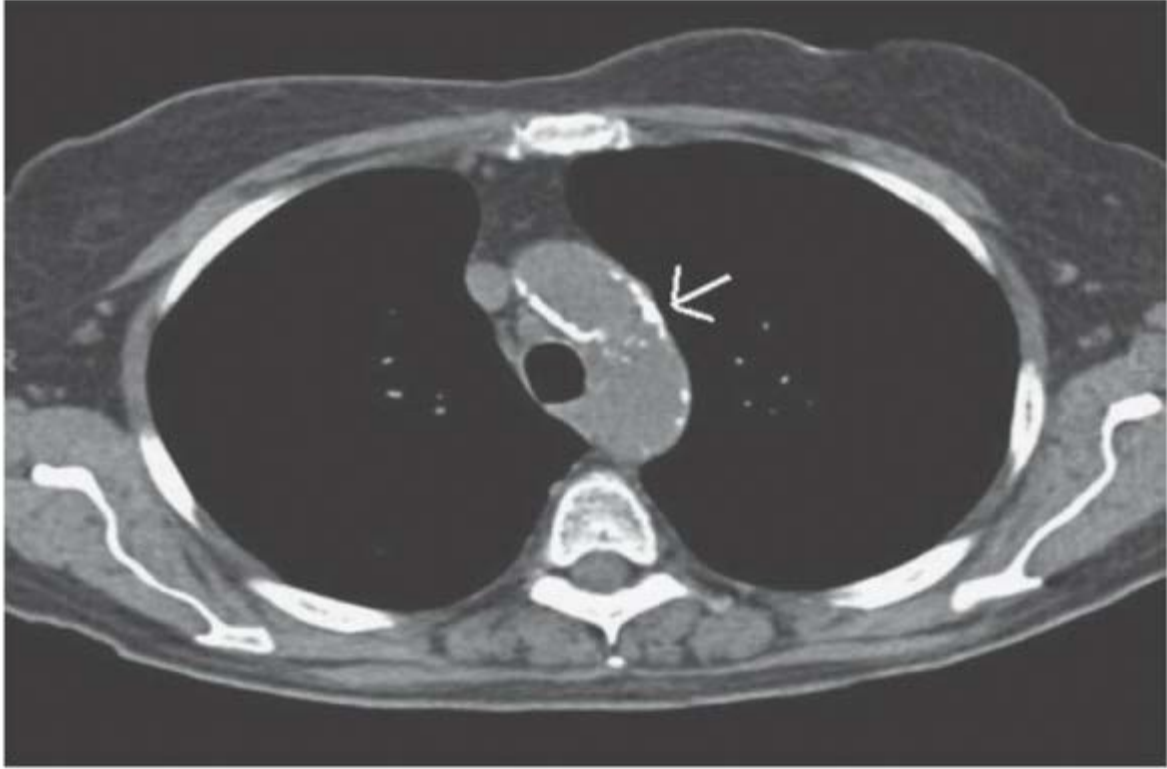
CT scan demonstrating a calcified aorta (*white arrow*).
